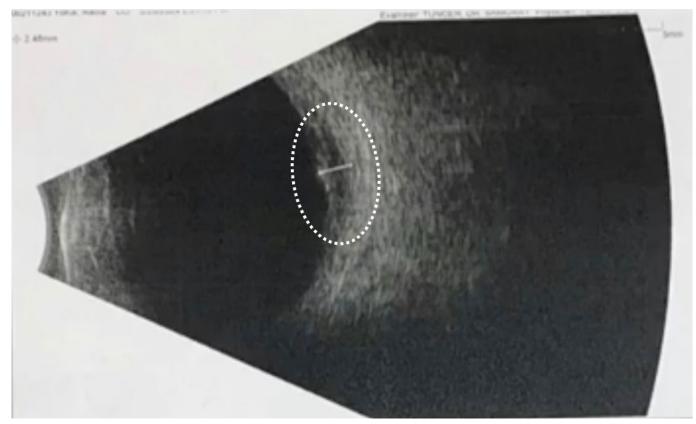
Ultrasonography showed mild choroidal thickening and serous detachment (dashed ring).
